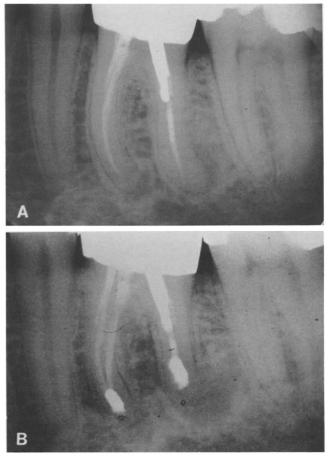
Mandibular first molar. *A*, Preoperative radiograph. Root canal treatment was performed 1 year before. The patient had a constant dull pain. There were periapical radiolucencies around the mesial and distal roots. Crown was constructed about 3 months previously. *B*, Postoperative radiograph. Note the retrograde amalgam fillings including the mesiobuccal and mesiolingual canals in the mesial root, and the distobuccal and distolingual canals in the distal root. The distolingual canal was not instrumented and filled during conventional root canal treatment.
